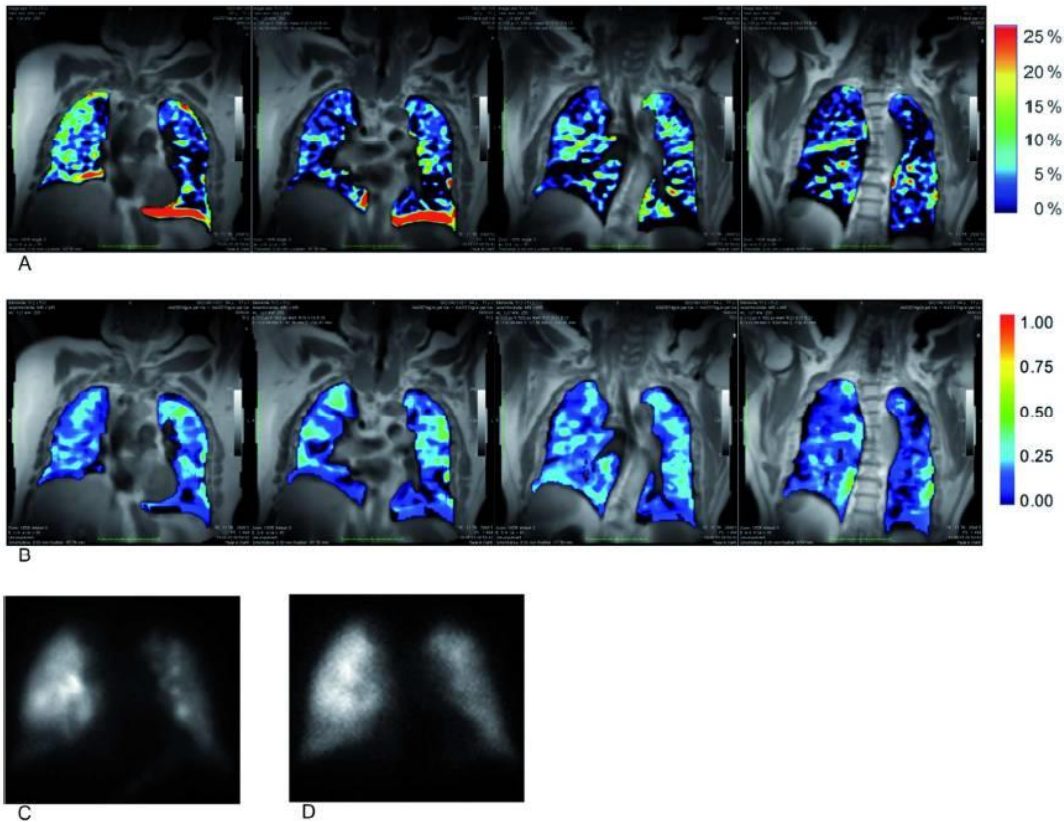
78-year-old male patient. A: RSE maps with an overall lower SI in the left lung and an inhomogeneous enhancement accentuated in the lower right lung. B: CCC maps with relatively similar impression compared to the RSE maps. C: Ventilation scintigraphy with lowered ventilation in the left lung and in the lower right lung. D: Perfusion scintigraphy with perfusion defects similar to the ventilation scintigraphy.
